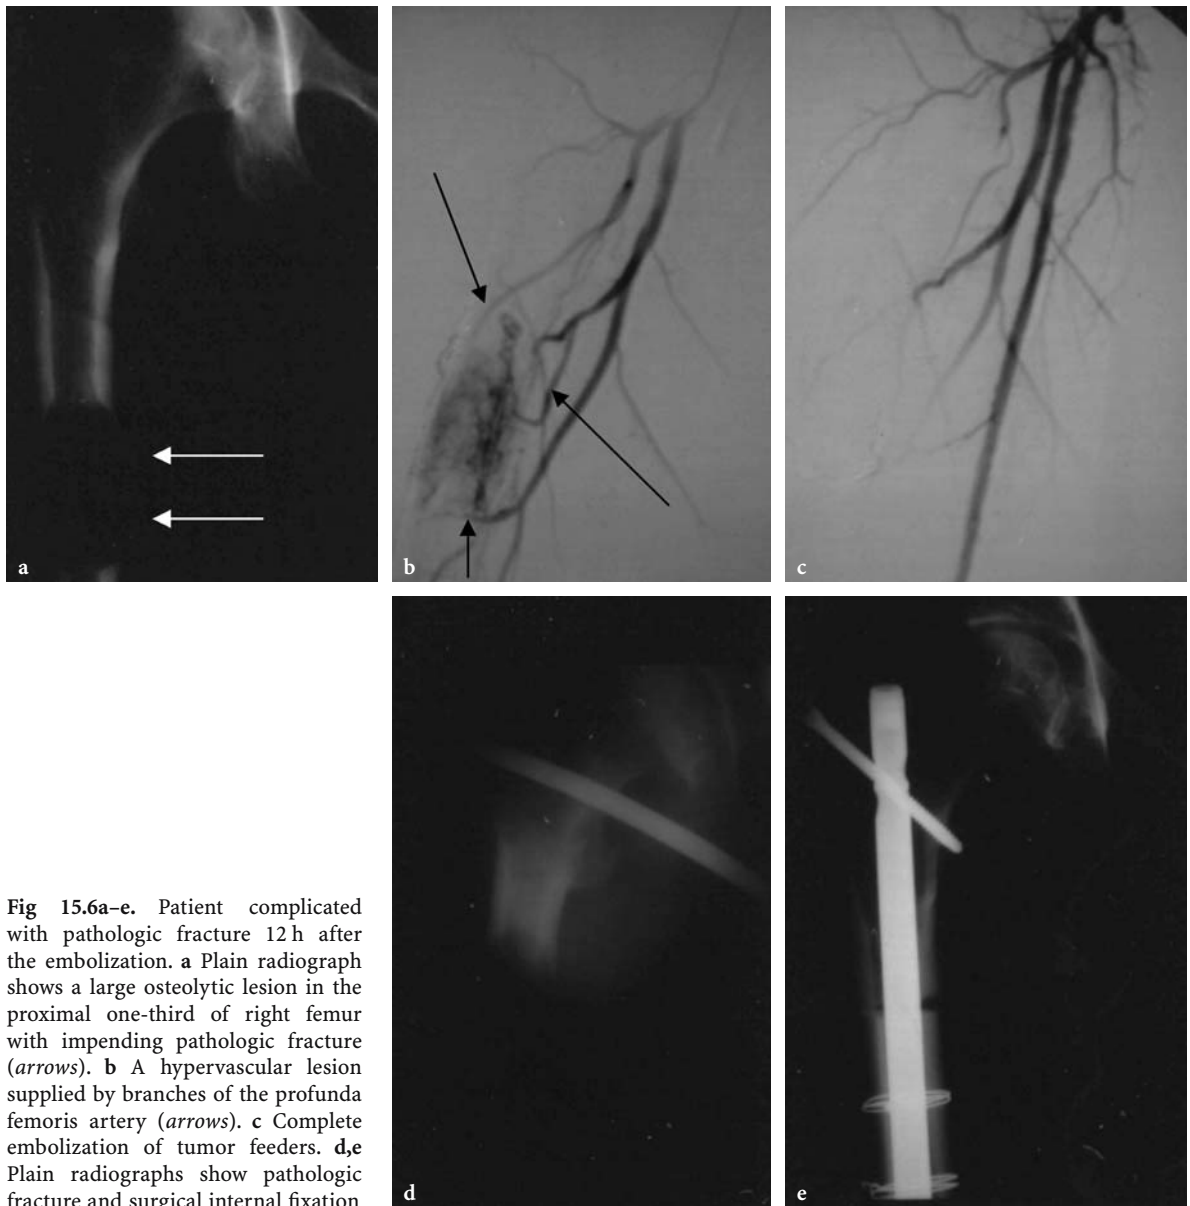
Patient complicated with pathologic fracture 12 h after the embolization. a Plain radiograph shows a large osteolytic lesion in the proximal one-third of right femur with impending pathologic fracture (*arrows*). b A hypervascular lesion supplied by branches of the profunda femoris artery (*arrows*). c Complete embolization of tumor feeders. d,e Plain radiographs show pathologic fracture and surgical internal fixation
